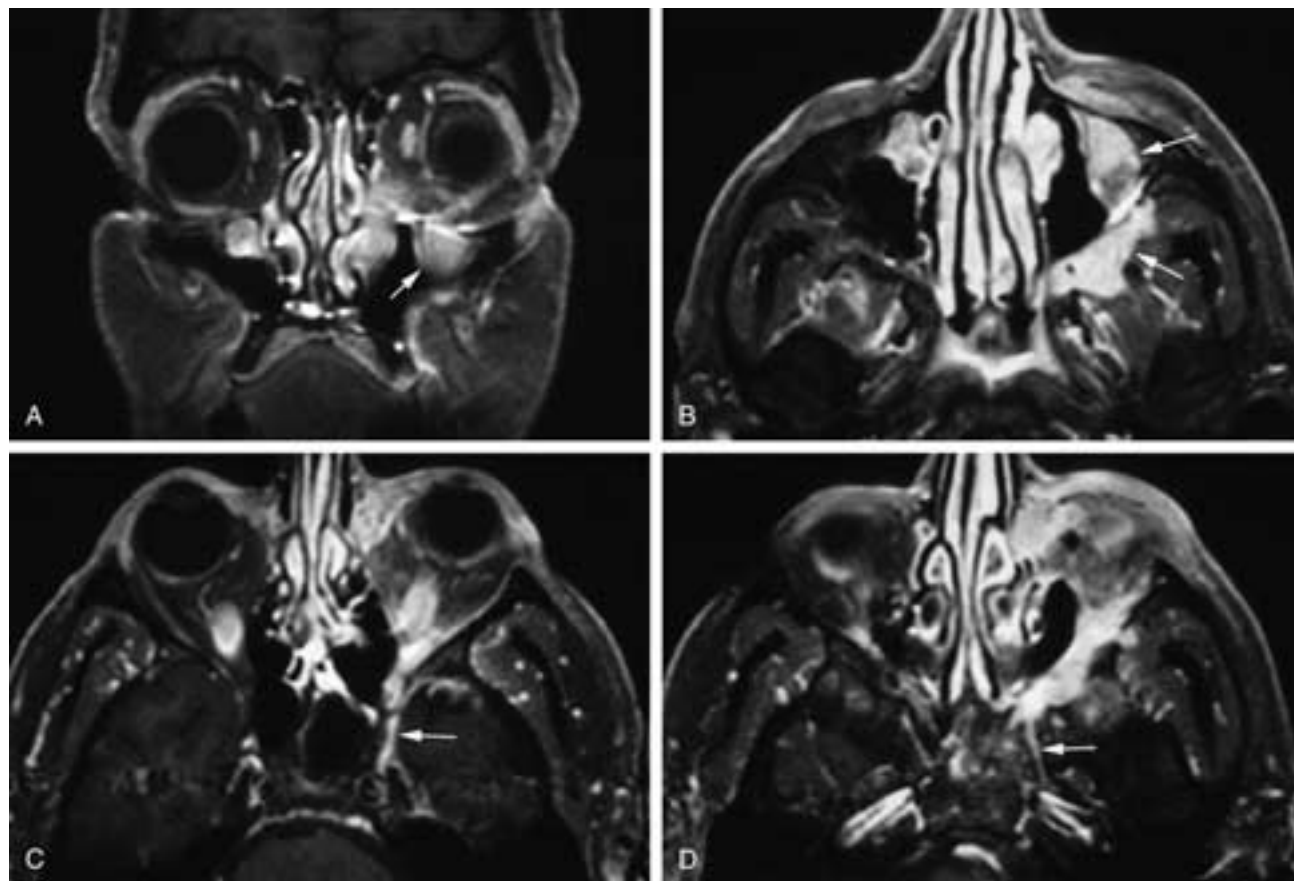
A series of T1-weighted, fat-suppressed, contrast-enhanced MR images. In a coronal view (A), a tumor mass is seen in the upper medial lower left maxillary sinus, the left ethmoid complex, and the orbit. Tumor also is seen in the infraorbital nerve (arrow). An unrelated inverted papilloma is also present in the upper medial right antrum. In an axial view (B) the tumor is seen extending along the course of V_2 (arrows). In an axial view (C) the tumor extends along V_2 in the left cavernous sinus (arrow). In an axial view (D) the tumor extends along the vidian nerve (arrow). This patient had a squamous cell carcinoma.
